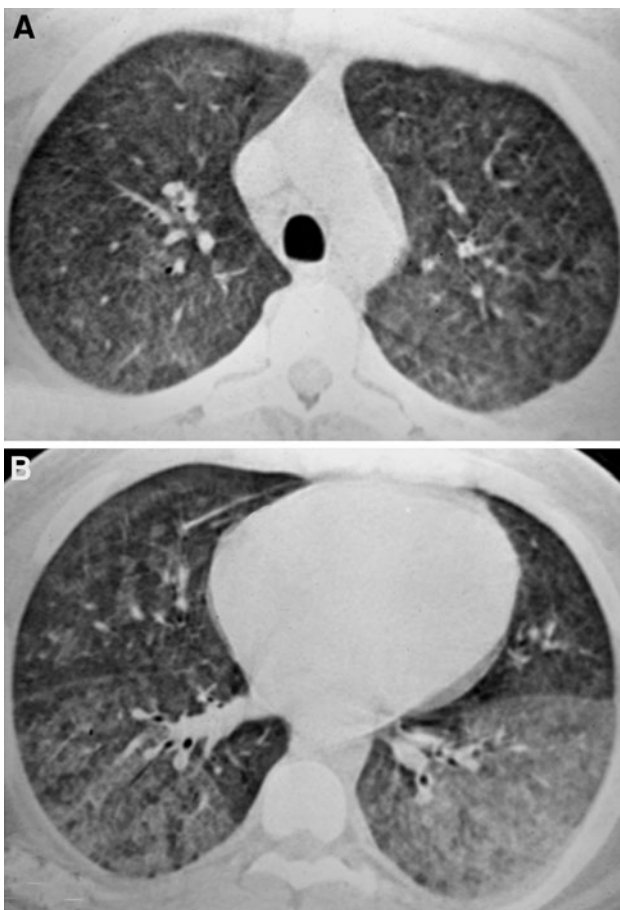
A 41-year-old man with leptospirosis and diffuse alveolar hemorrhage. High-resolution computed tomography at the levels of the upper (a) and lower (b) lobes shows bilateral ground-glass opacities in both lungs
